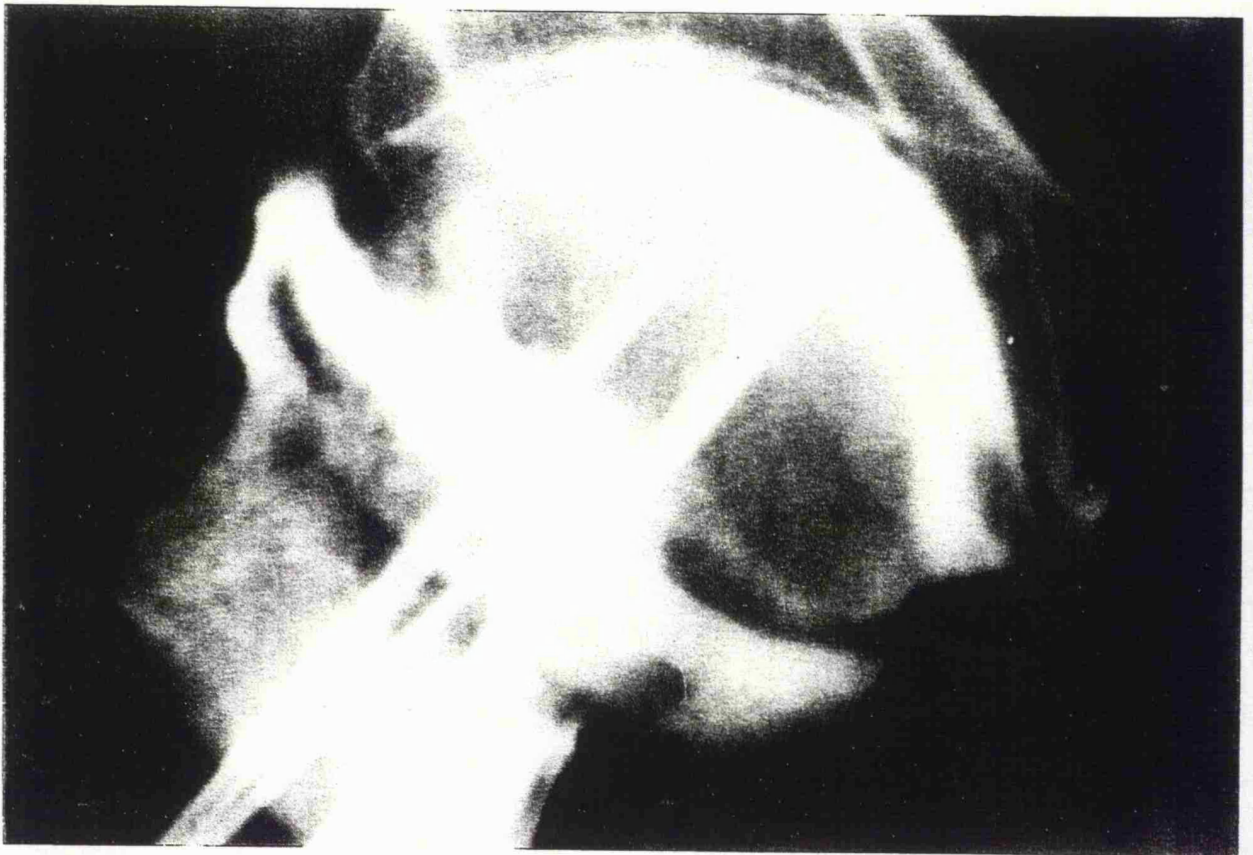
Antero-posterior radiograph showing arthrogram confirming intra-articular placement of cannula.
